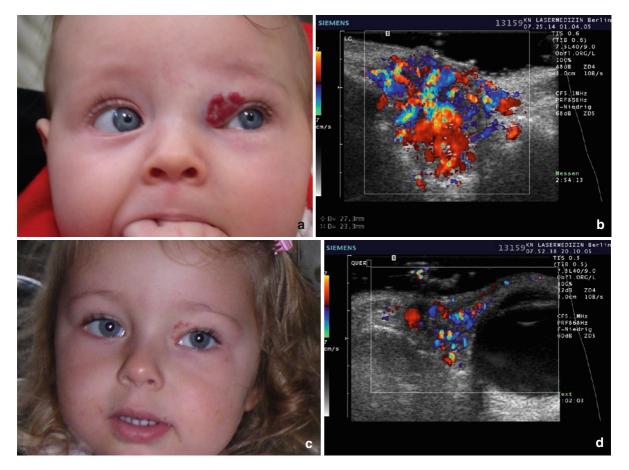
(a) Besides a cutaneous infiltration the subcutaneous volume hinders the eyelid motility. (b) Color-coded duplex sonography detects the deep infiltration medial of the bulb. (c)
